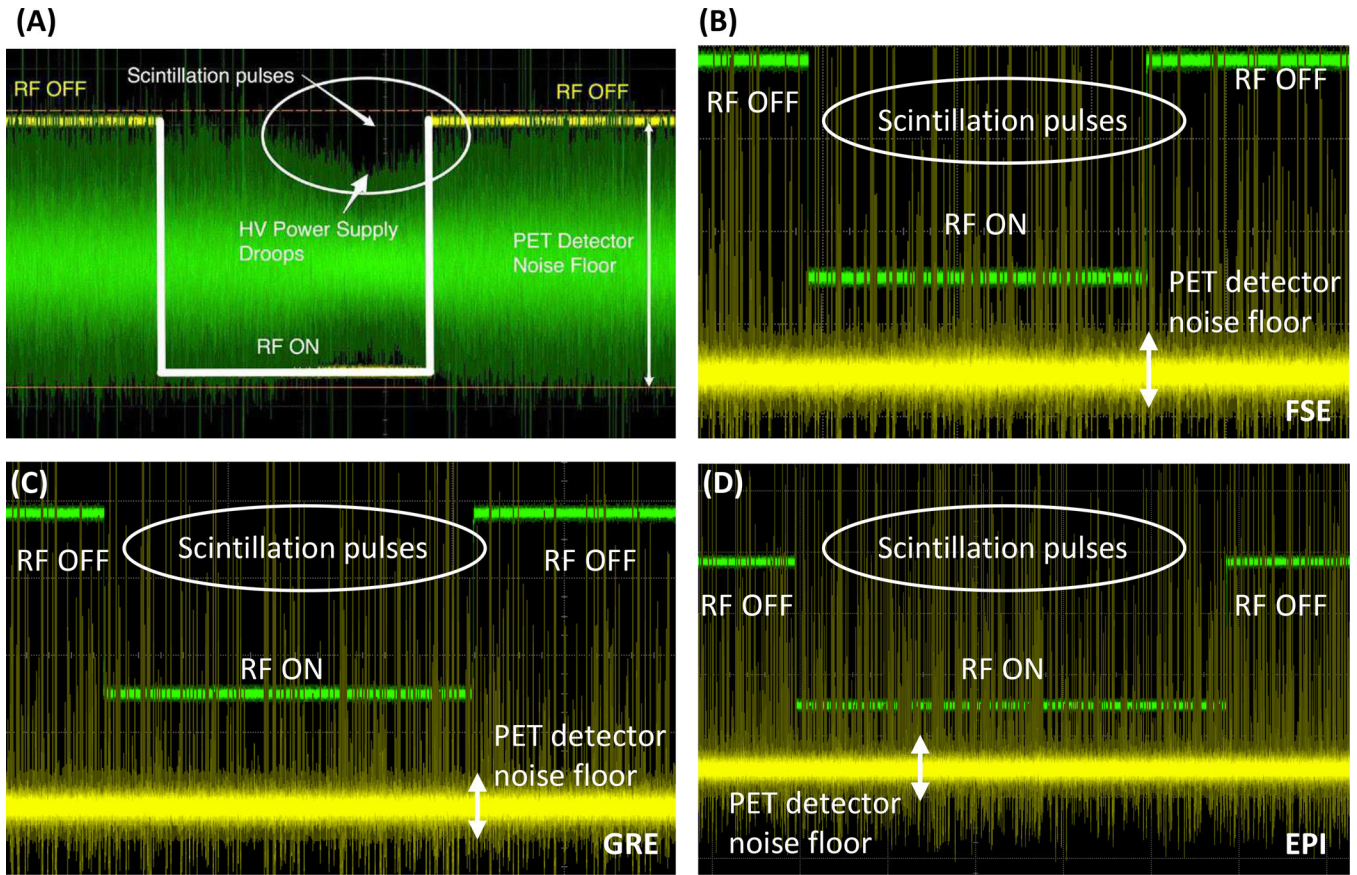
Waveforms of the output of a VCSEL in the PET detector module captured by a high performance digital storage oscilloscope synchronized to the RF trigger of the MRI system. (A) Waveform captured without the SiPM bias voltage regulator module during FSE sequence (adapted with permission from [44]). (B–D) Waveforms captured after implementing the voltage regulator module during FSE (B), GRE (C), and EPI (D) sequences. X-axis unit: 1 ms/interval. Y-axis unit: 50 mV/interval in (A) and 100 mV/interval in (B–D) (VCSEL output) and 1 V/interval (MRI RF pulse). The fact that there is no change to the analog PET detector pulses or noise floor with RF on or off as seen on oscilloscope waveforms is perhaps the strongest evidence to support the claim that the PET detectors are free of interference from the MR system.
